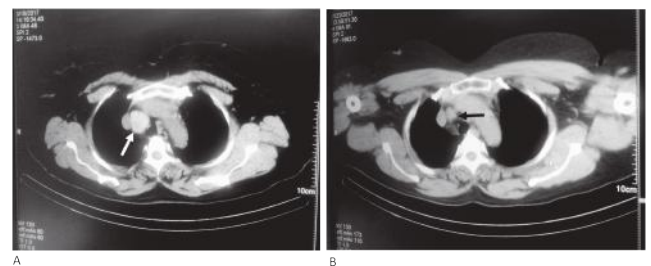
CT images of neck and chest before and after radioiodine treatment. (A) Before ^{131}I treatment, CT section shows a large soft tissue density mass (3.1 X 2.9 cm) in superior mediastinum (white arrow). (B) Three months after ^{131}I treatment, the CT showed significant reduction of the size (1.4 X 1.2 cm) of the mass (black arrow).
